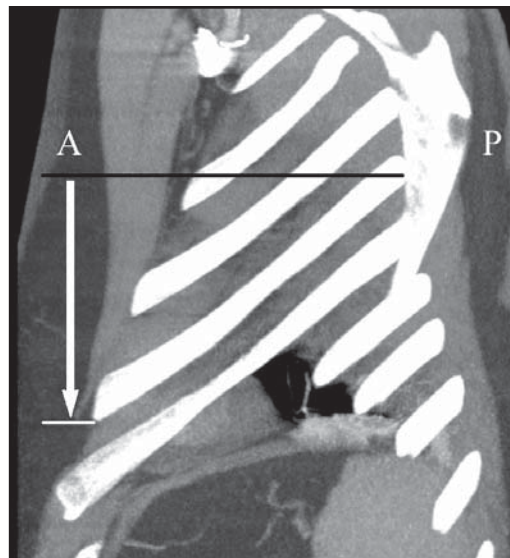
Sagittal CT image of the chest. This reformatted image demonstrates the posterior (P) to anterior (A) descent of the ribs as they wrap around the body. The distance between the 2 lines represented by the arrow is approximately 3 to 5 inches in most individuals.
